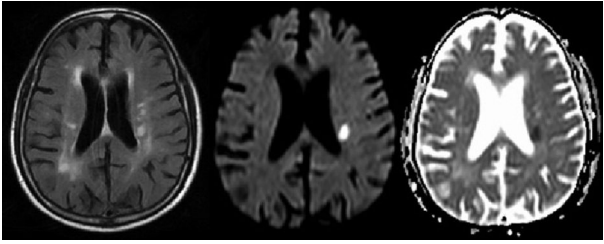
MRI of an acute lacunar infarct. From left to right the scans show FLAIR and diffusion-weighted (DWI) images and an apparent diffusion coefficient (ADC) map. An acute lacunar infarct in the left corona radiata can be seen as high signal on DWI and corresponding low signal on the ADC map. It is in the corona radiata and resulted in right hemiparesis owing to disruption of the corticospinal tract. © Hugh Markus.
